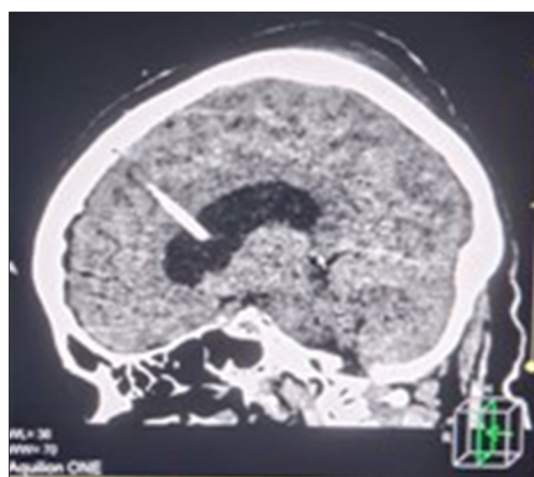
Final control computed tomography scan, with the ventricular catheter in the proper position.
